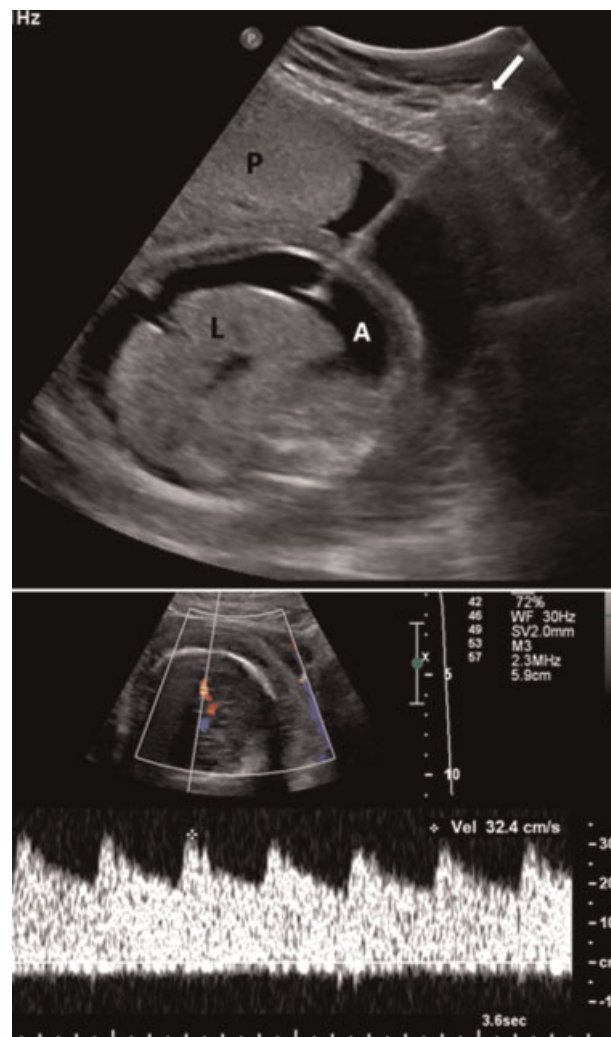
(Upper panel) Peritoneal aspiration and transfusion. The white arrow delineates the needle inserted into fetal abdomen for drainage of ascites and intraperitoneal transfusion. (Lower panel) Posttransfusion middle cerebral artery Dopplers. The peak systolic velocity is within normal range for this gestation; however, very high diastolic flow is seen. A, hemorrhagic ascites; L, fetal liver; P, hydropic placenta.
